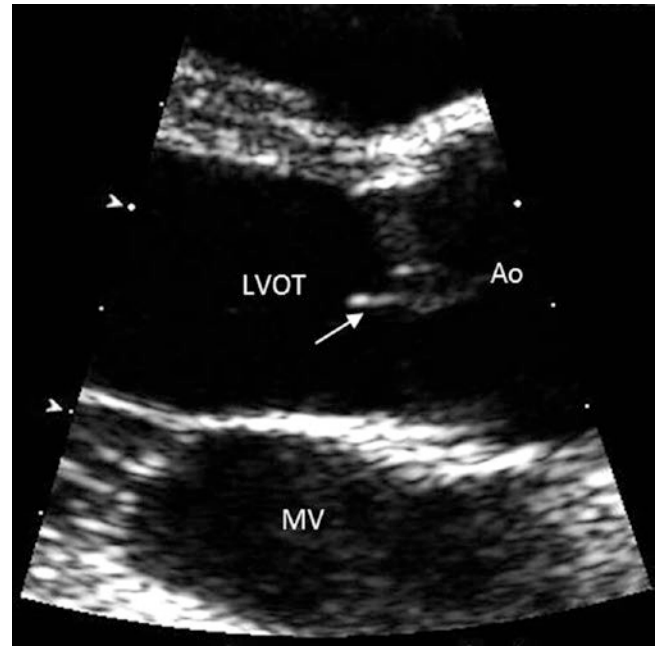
Parasternal long axis POC imaging of a 70-year-old man with recent history of palpitations. The mass (*arrow*) measured 3.5 mm in diameter, was highly mobile and attached to the interventricular septum with a stalk. It is located at the closure margin of aortic valve without any regurgitation. This is an example of Lambl's excrescence, which are thin, mobile filiform structures located at valve closures. They are thought to be degenerative processes with low risk of embolization. *Ao* aorta, *LVOT* left ventricular outflow tract, *MV* mitral valve
